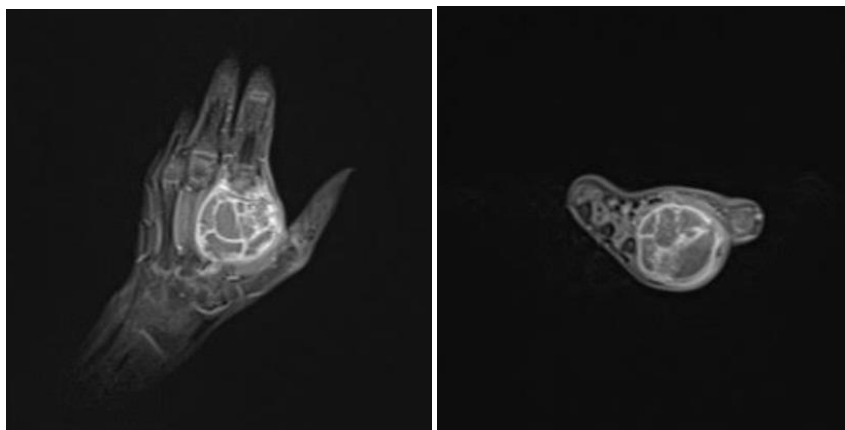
MRI of the right hand after gadolinium administration, T1 DIXON fat-suppressed sequence: peripheral and septal enhancement of the lesion
